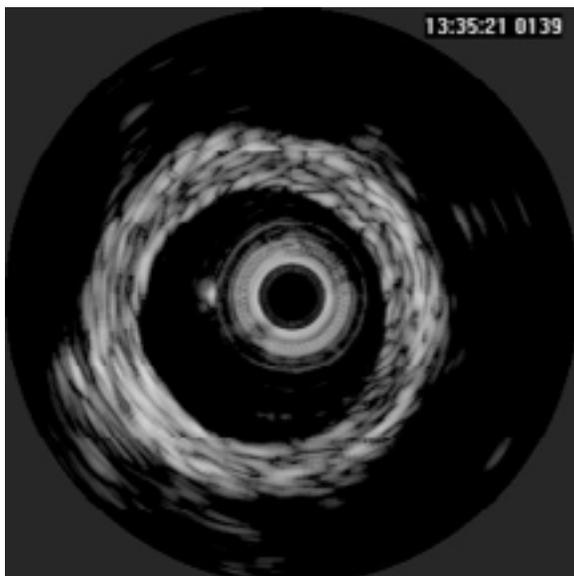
Intravascular ultrasound image of the aorta. Three layers of vessel wall are visible: intima, media and adventitia.
